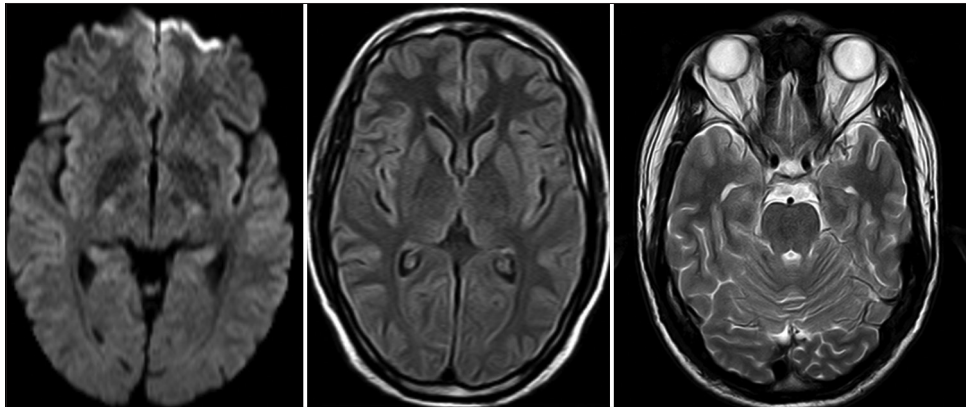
Repeat magnetic resonance imaging brain with contrast showing no parenchymal, meningeal, or vascular abnormalities
